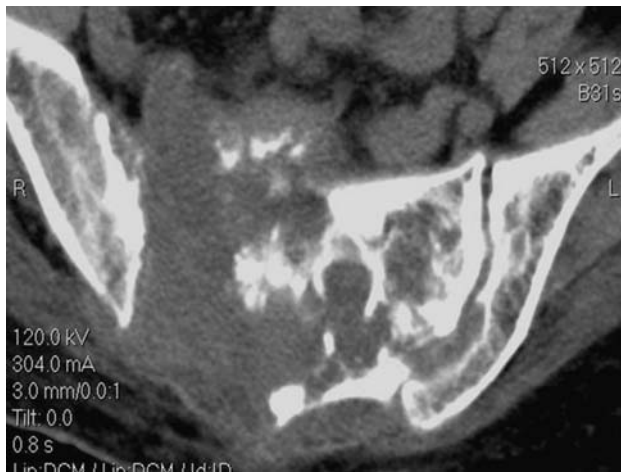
A comparative axial CT scan at 4 months' followup shows little additional mineralization in the lesion with no further bone destruction.
